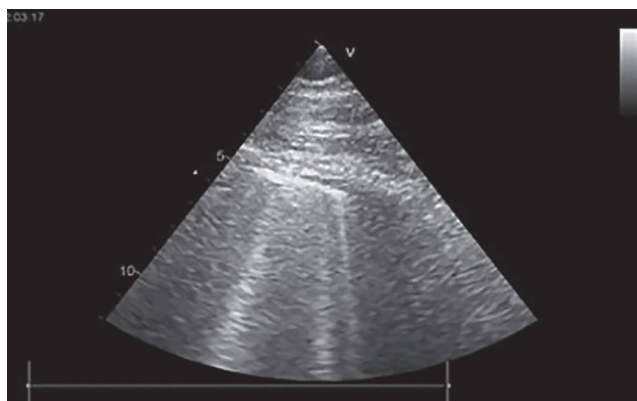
Lung ultrasound. Multiple B-lines.
